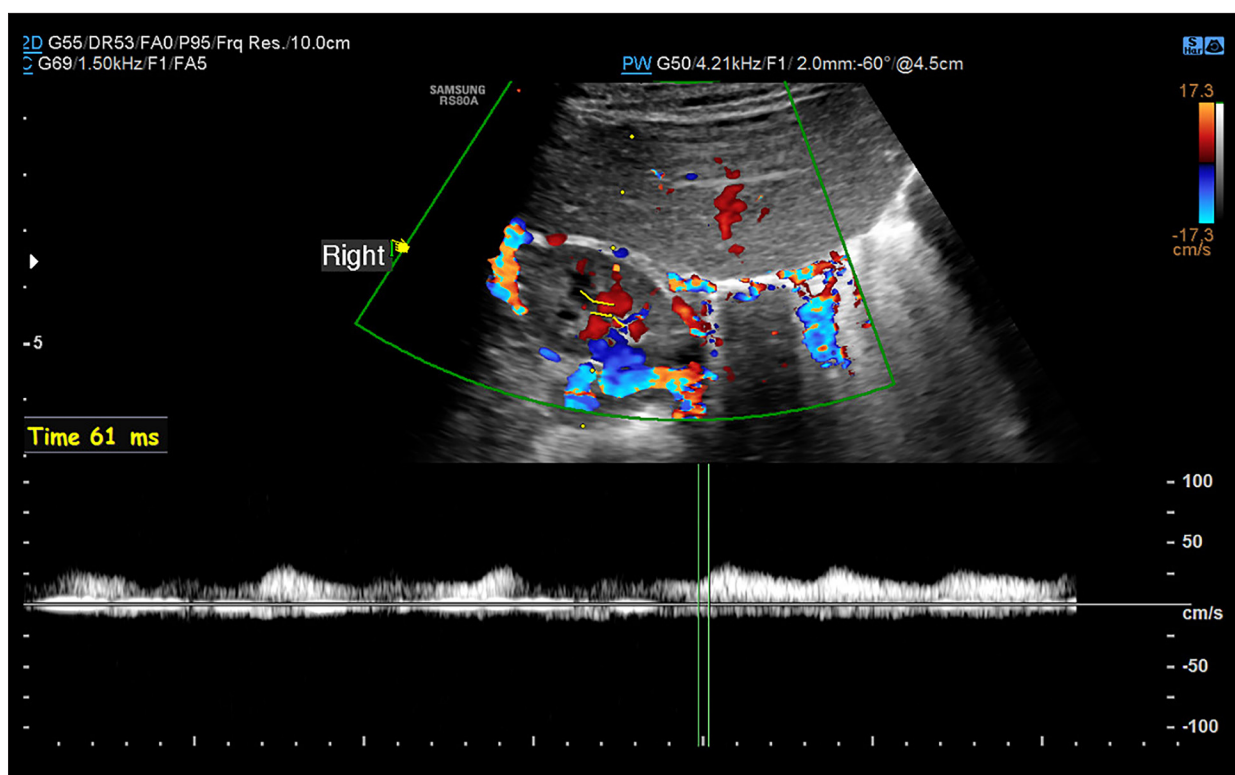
Doppler ultrasound of the renal arteries in a 4-year-old girl. The right renal artery was significantly narrower than the left (1.6 mm vs 2.6 mm). Doppler waveforms in the right segmental arteries demonstrated a tardus–parvus pattern, with prolonged acceleration time compared with the left kidney (61 ms vs 33 ms). The resistive index was lower on the right (0.31 vs 0.61), while peak systolic velocity was 32 cm/s on the right and 25 cm/s on the left.
